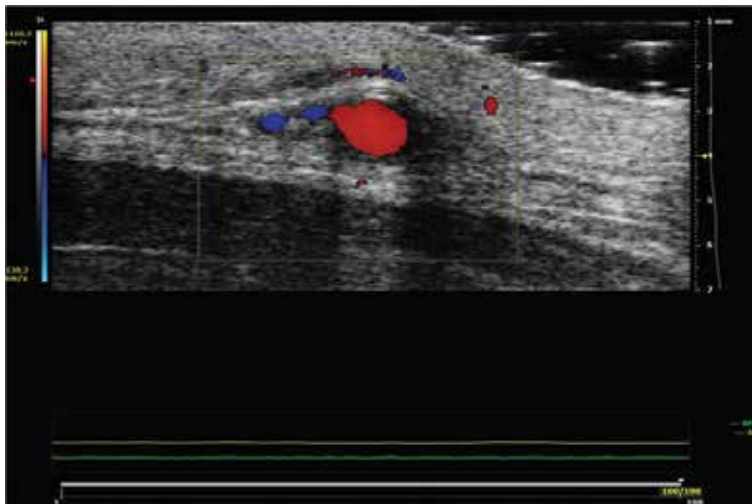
Example of color Doppler image showing flow through temporal artery. Obtained using 50 MHz transducer. Used with permission from Gholam A. Peyman.
